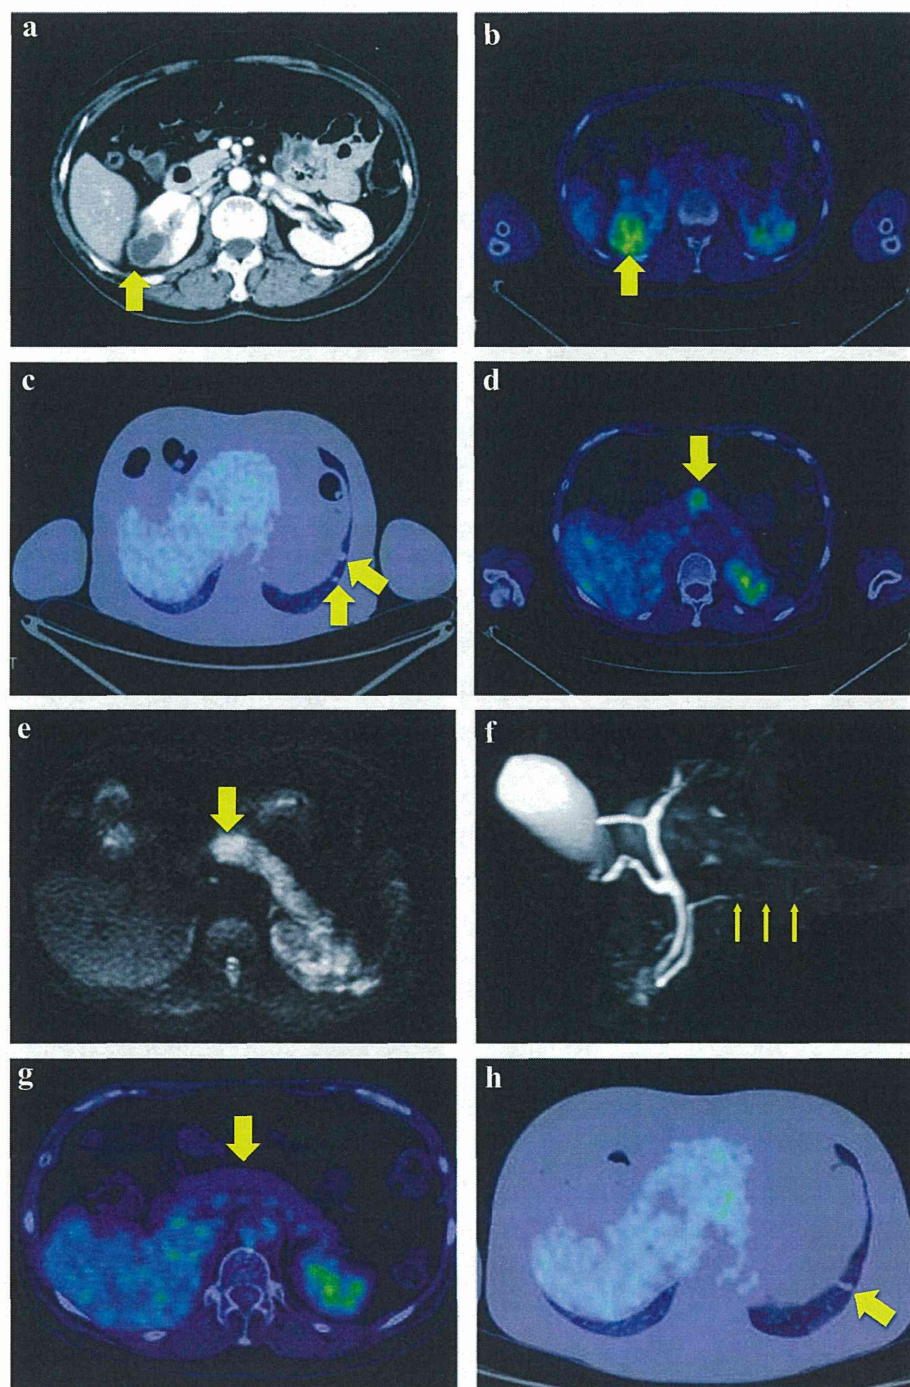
Imaging findings. a. Abdominal computed tomography scan shows 31×24 mm cystic lesion in right kidney (arrows). b. PET/CT scan showed moderate FDG accumulation of cystic lesion in right kidney (arrows). c. PET/CT scan showed moderate FDG accumulation of lung tumor (arrows). d. PET/CT scan showed moderate FDG accumulation of pancreatic body (arrows). e. Diffusion-weighted MRI showed high intensity area in pancreatic body (arrows). f. MRCP showed irregular narrowing in main pancreatic duct (arrows). g. PET/CT scan demonstrated a decrease of FDG accumulation in pancreatic body (arrows). h. PET/CT scan demonstrated a decrease of FDG accumulation in lung tumor (arrows).
